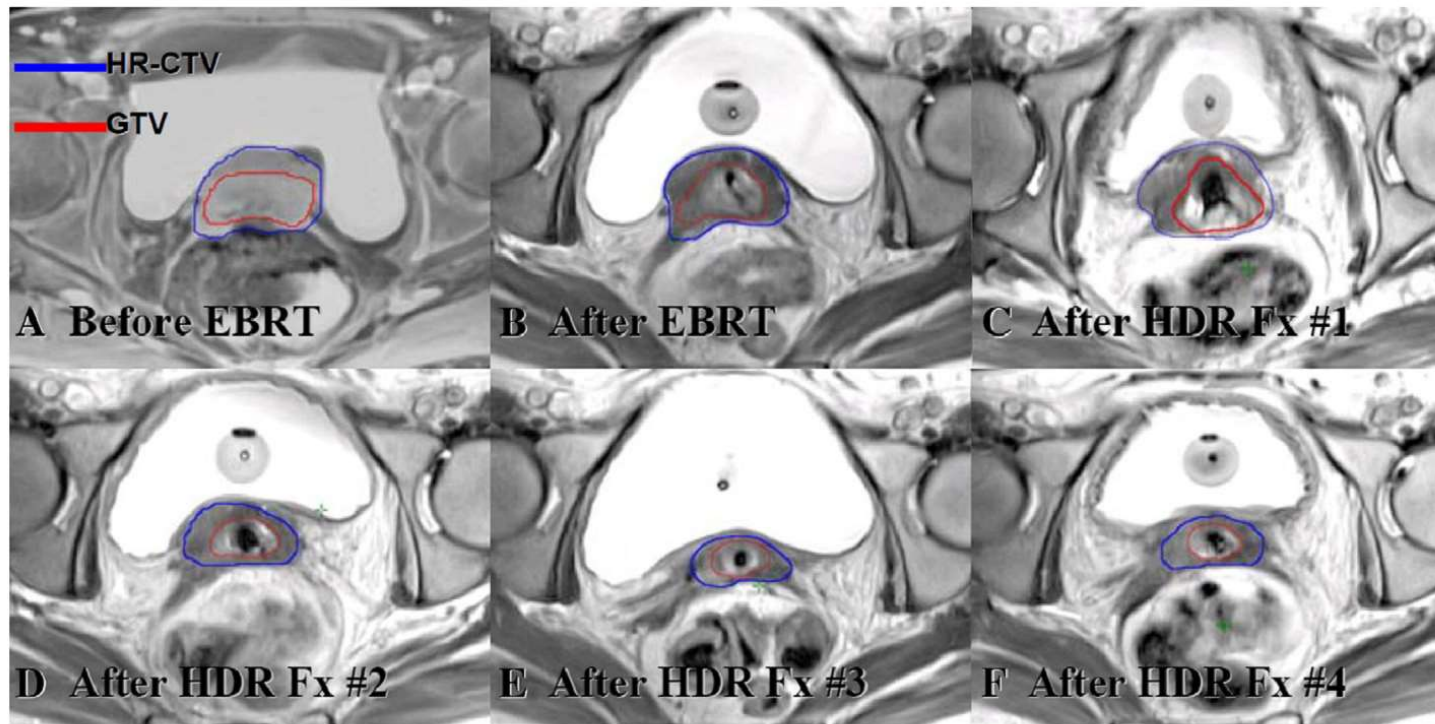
The T2-weighted magnetic resonance imaging data sets for 1 patient showing gross target volume (GTV) and high-risk clinical target volume (HR-CTV) (A) before external beam radiation therapy (EBRT), (B) regression after EBRT, and (B)-(F) after each brachytherapy fraction of high-dose-rate (HDR). (A) 1.5 Tesla MRI images were used for EBRT planning and (B)-(F) 3.0 Tesla MRI images were used for HDR planning.
